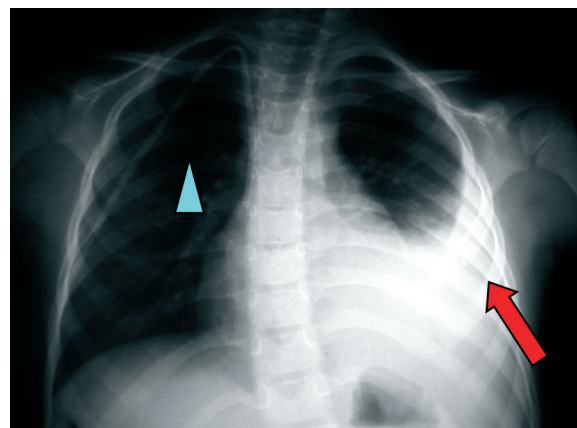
Chest radiograph (posteroanterior projection) performed to assess the cause of pleuritic chest pain. The arrow points to a left pleural effusion and the arrowhead points to the Hickman catheter.
